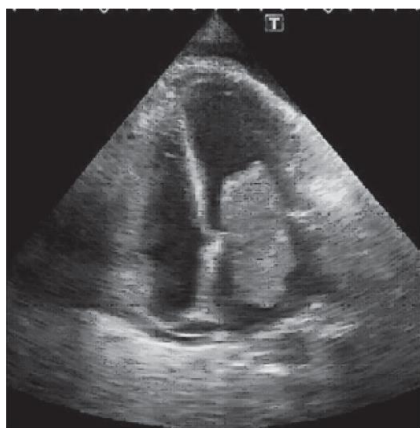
Echocardiographic signs of a large mass neoplasm of the left atrium, prolapsing into the cavity of the left ventricle and obstructing the mitral valve
